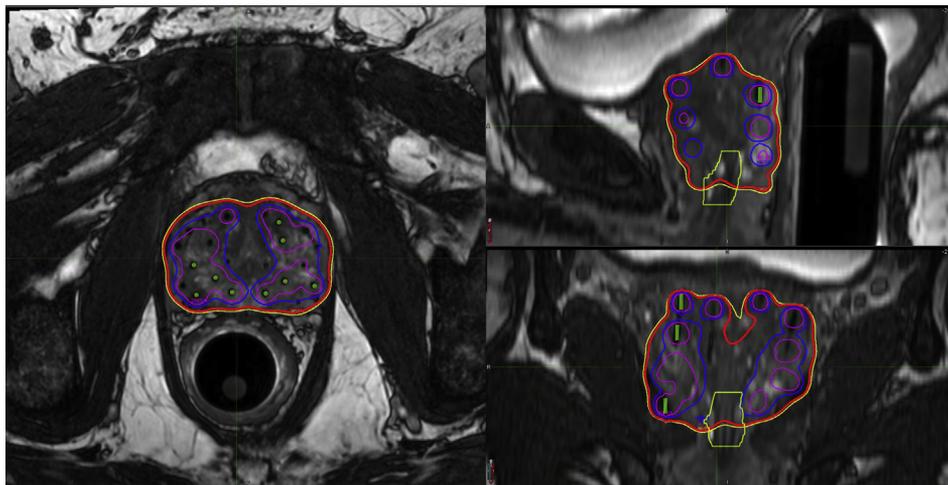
External urinary sphincter sparing with MR planning. MRI allows us to visualize and account for the EUS during planning. Sparing of the EUS in addition to the reduction of expansion necessary to acquire the planning target volume (PTV) results in implants with reduced activity-to-volume ratio while maintaining appropriate coverage and dose.
